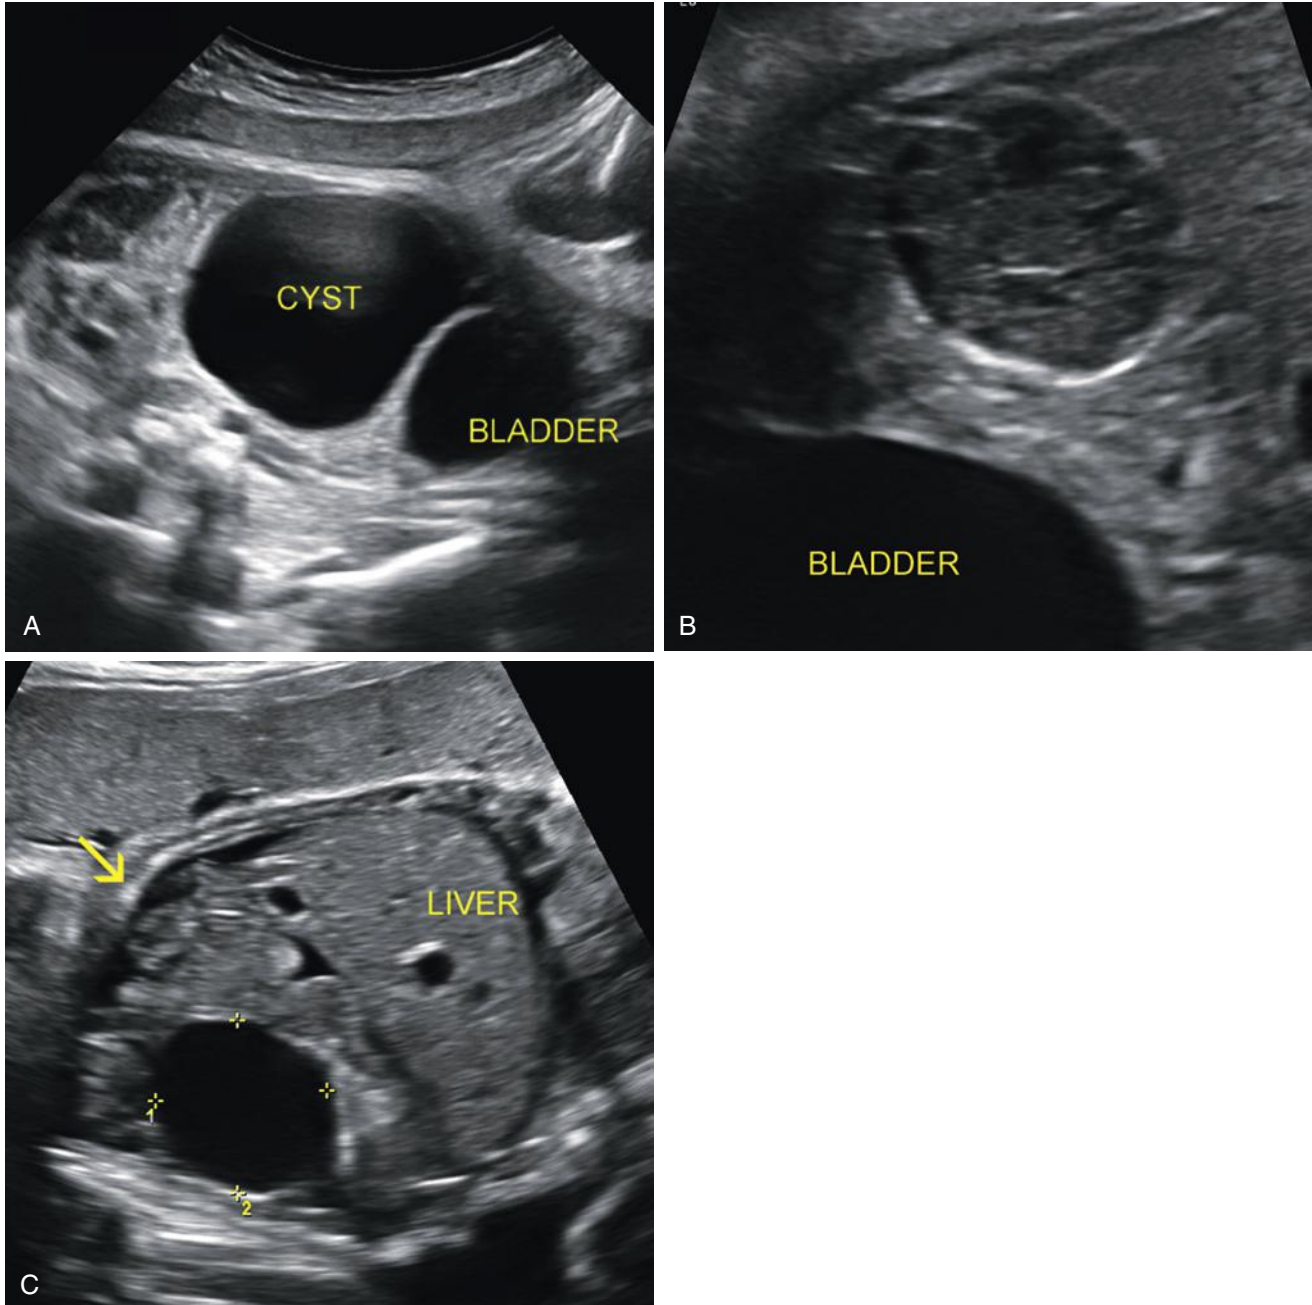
Ovarian cyst. A, Large thin-walled anechoic cyst, first seen at 36 weeks, adjacent to the urinary bladder. Color Doppler sonography can be used to identify the bladder, flanked by the umbilical arteries. The child underwent percutaneous drainage of the cyst 1 week after birth, but the fluid reaccumulated. Surgical excision was performed at 11 weeks of age and ovarian torsion with necrosis was found. B, A 3-cm ovarian cyst, with internal echoes and strands suggesting hemorrhage, adjacent to the bladder. C, A 4-cm unilocular thin-walled anechoic ovarian cyst (*cursors*) seen at 36 weeks. Mild ascites (*arrow*) also present. The ascites rapidly resolved, and the cyst gradually involuted postnatally. The child did not require surgery.
